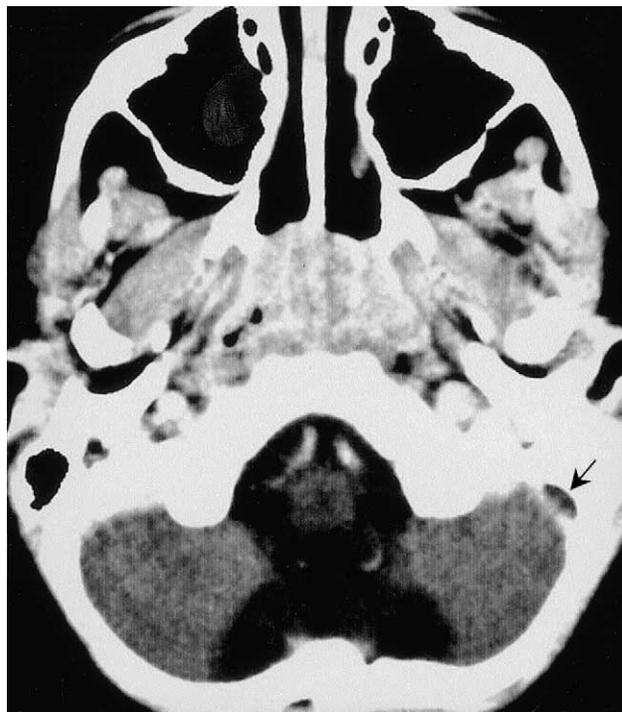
Contrast-enhanced axial CT scan shows a filling defect at level of left sigmoid sinus (arrow), consistent with thrombosis.
